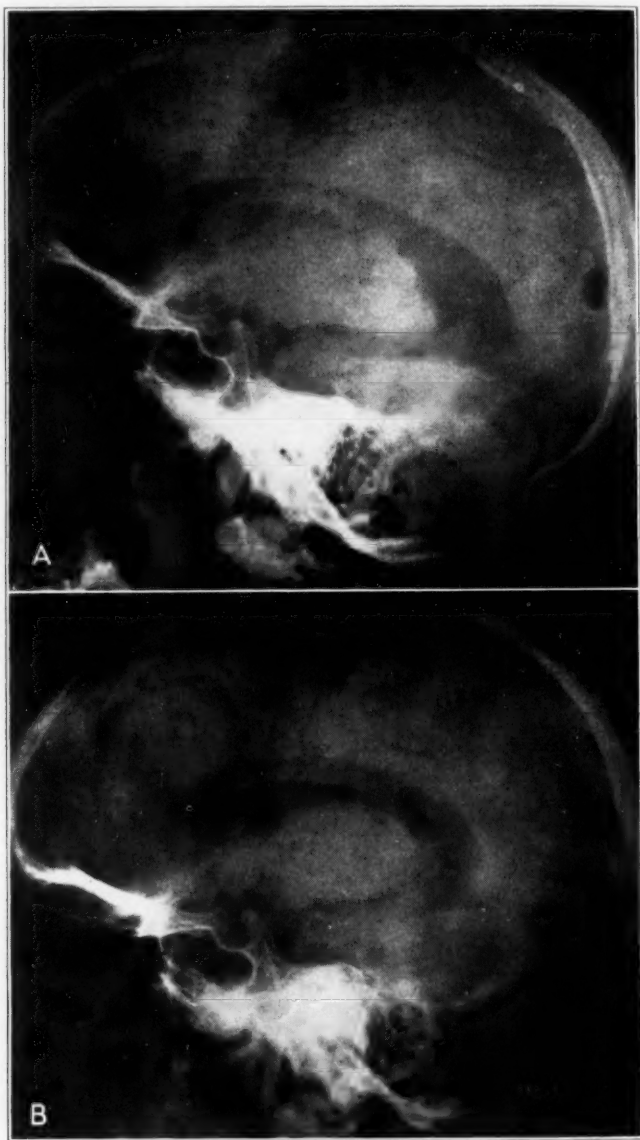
Lateral roentgenograms of the normal temporal horn, showing (A) the body and the supracornual cleft near the tip of the horn only and (B) the supracornual cleft, and not the body.
